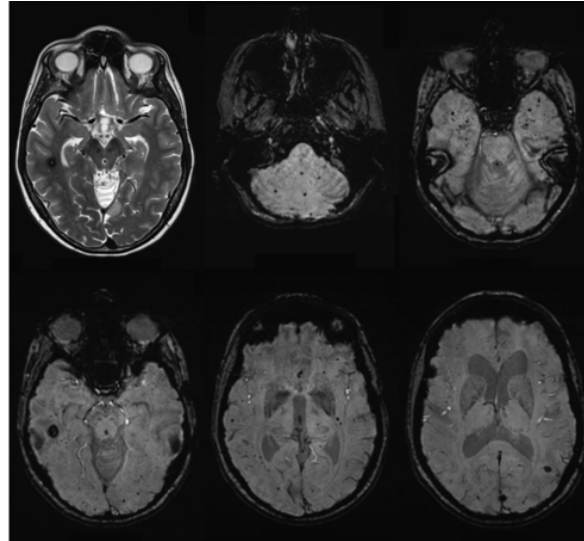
MRI revealed cerebral microbleeds in a 37-year-old, 28 years after surviving childhood cancer.
